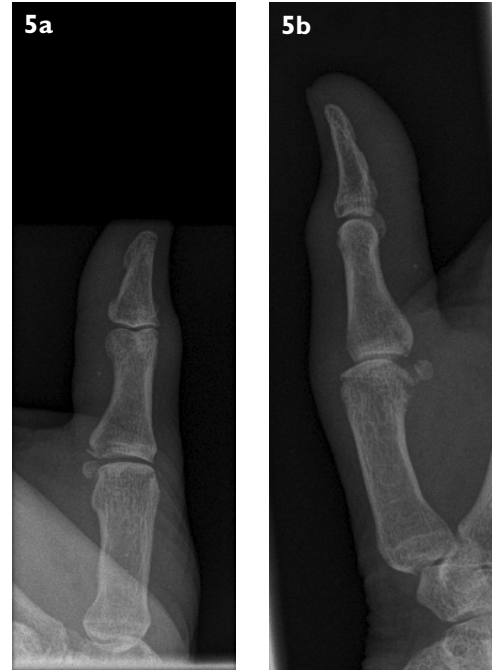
(a) Anteroposterior and (b) lateral radiographs of the right thumb show well-aligned metacarpophalangeal and interphalangeal joints at six weeks' follow-up, with no associated complications.
